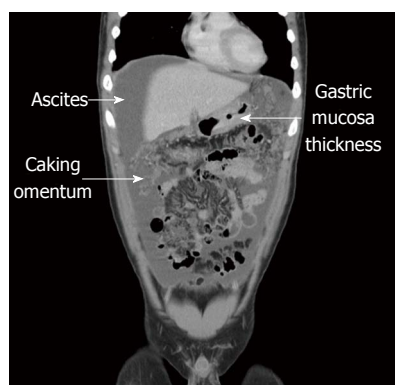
Massive ascites, gastric mucosa thickness, and caking omentum are shown by arrows on the coronal view of abdominal computed tomography.
